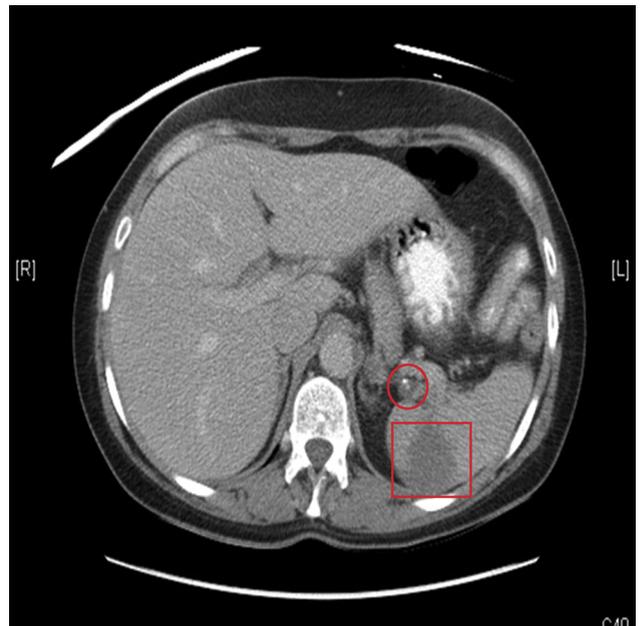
Figure Computed tomography scan of the abdomen without contrast showing splenic infarct (square) and thrombosed splenic artery aneurysm (circle).
